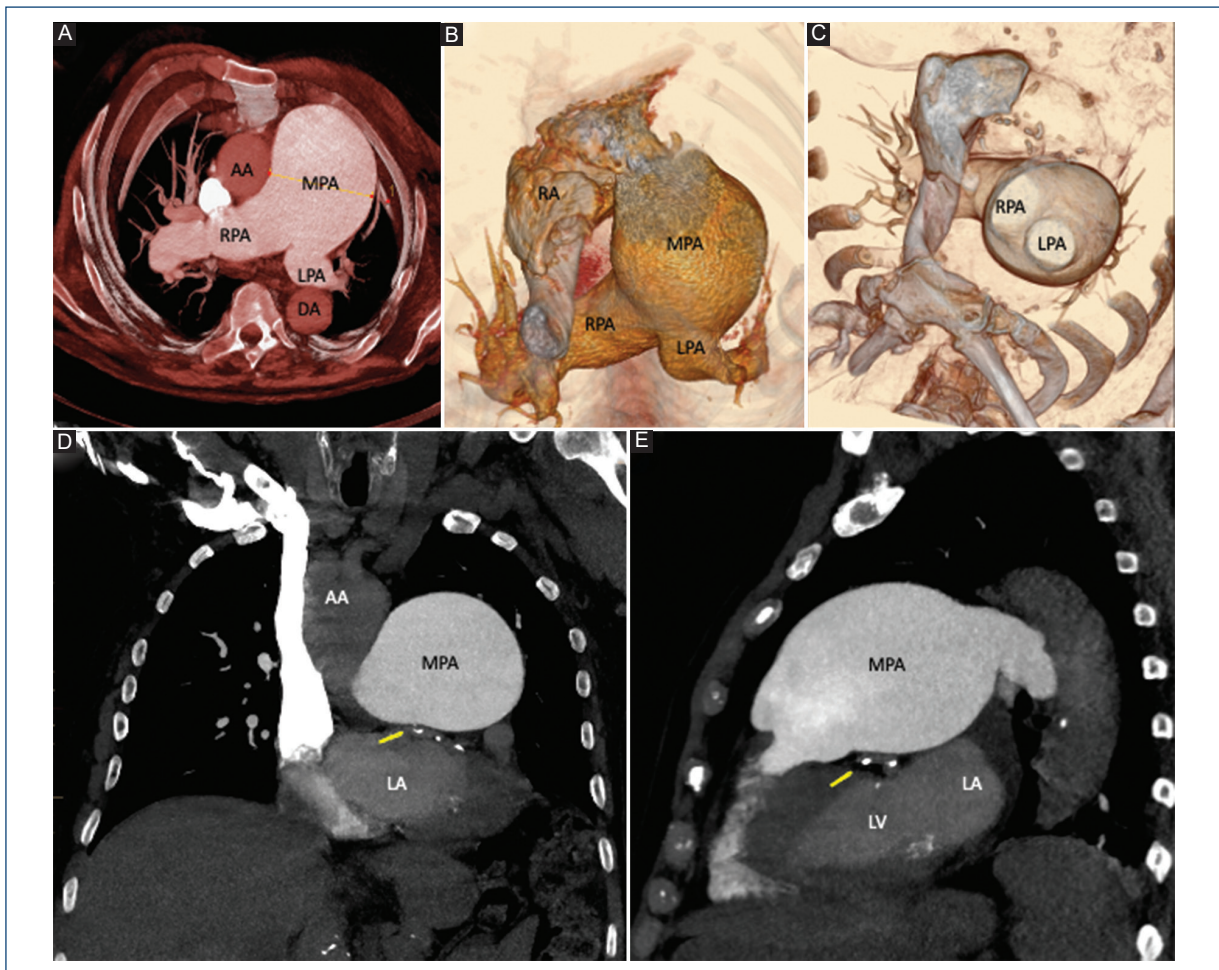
A-C: axial CT and three-dimensional reconstructions of the chest CT showing the main pulmonary artery aneurysm. D: coronal and sagittal E: MIP CT images demonstrate the pulmonary artery aneurysm in 2024 and its close relationship with the moderately calcified left coronary artery (yellow arrow). CT: computed tomography; AA: ascending aorta; DA: descending aorta; LA: left atrium; LV: left ventricle; MIP: maximum intensity projection; MPA: main pulmonary artery; RPA: right pulmonary artery; LPA: left pulmonary artery; RA: right atrium.
